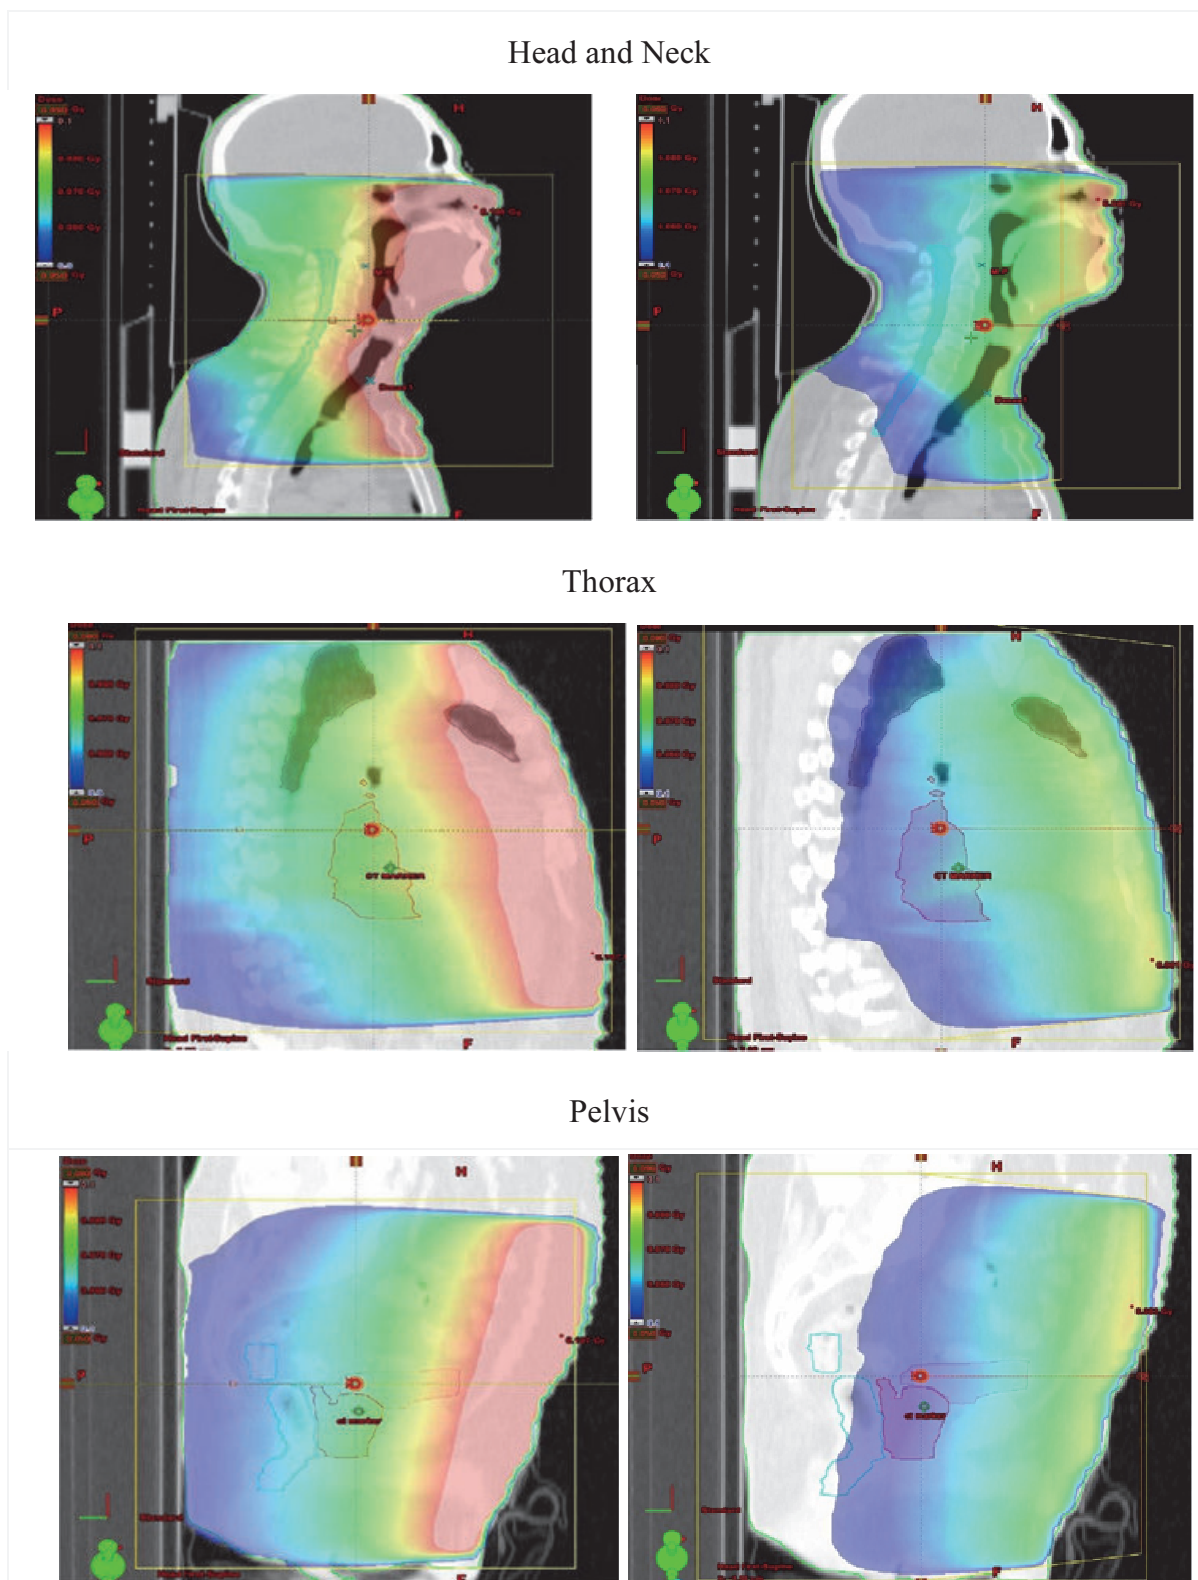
The 2D absolute dose distribution of sagittal central slice evaluated in various treatment sites using MV CBCT imaging with 8 MU (left panels) and orthogonal portal imaging with 6 MU (right panels).
